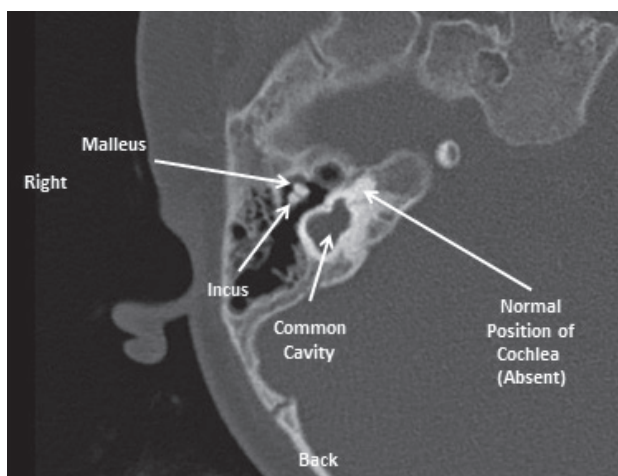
Axial CT image of the right temporal bone showing an absent cochlea and a cystic vestibule. No other discernible inner ear structures can be seen.
